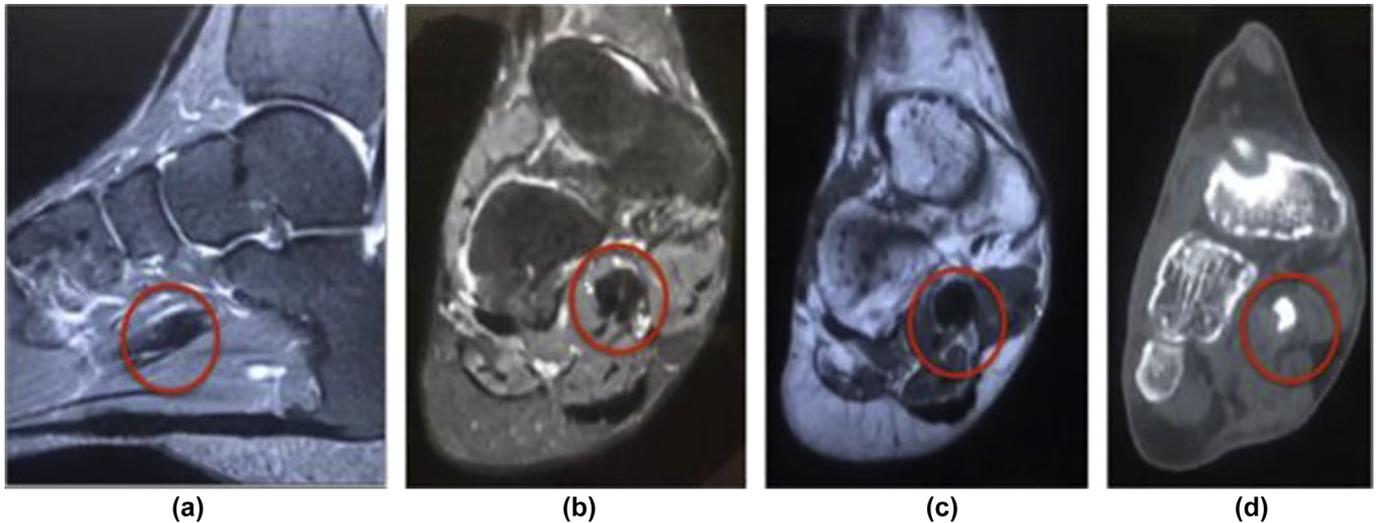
(a) STIR sagittal, (b) STIR coronal, (c) T1 coronal MRI, (d) coronal MPR computed tomography (CT) images show an example of chronic intersection syndrome with a large calcified loose body at the knot of Henry on both CT and MRI. Synovial osteochondromatosis within the knot of Henry tendon sheath is likely to have resulted from a chronic stenosing tenosynovitis.
